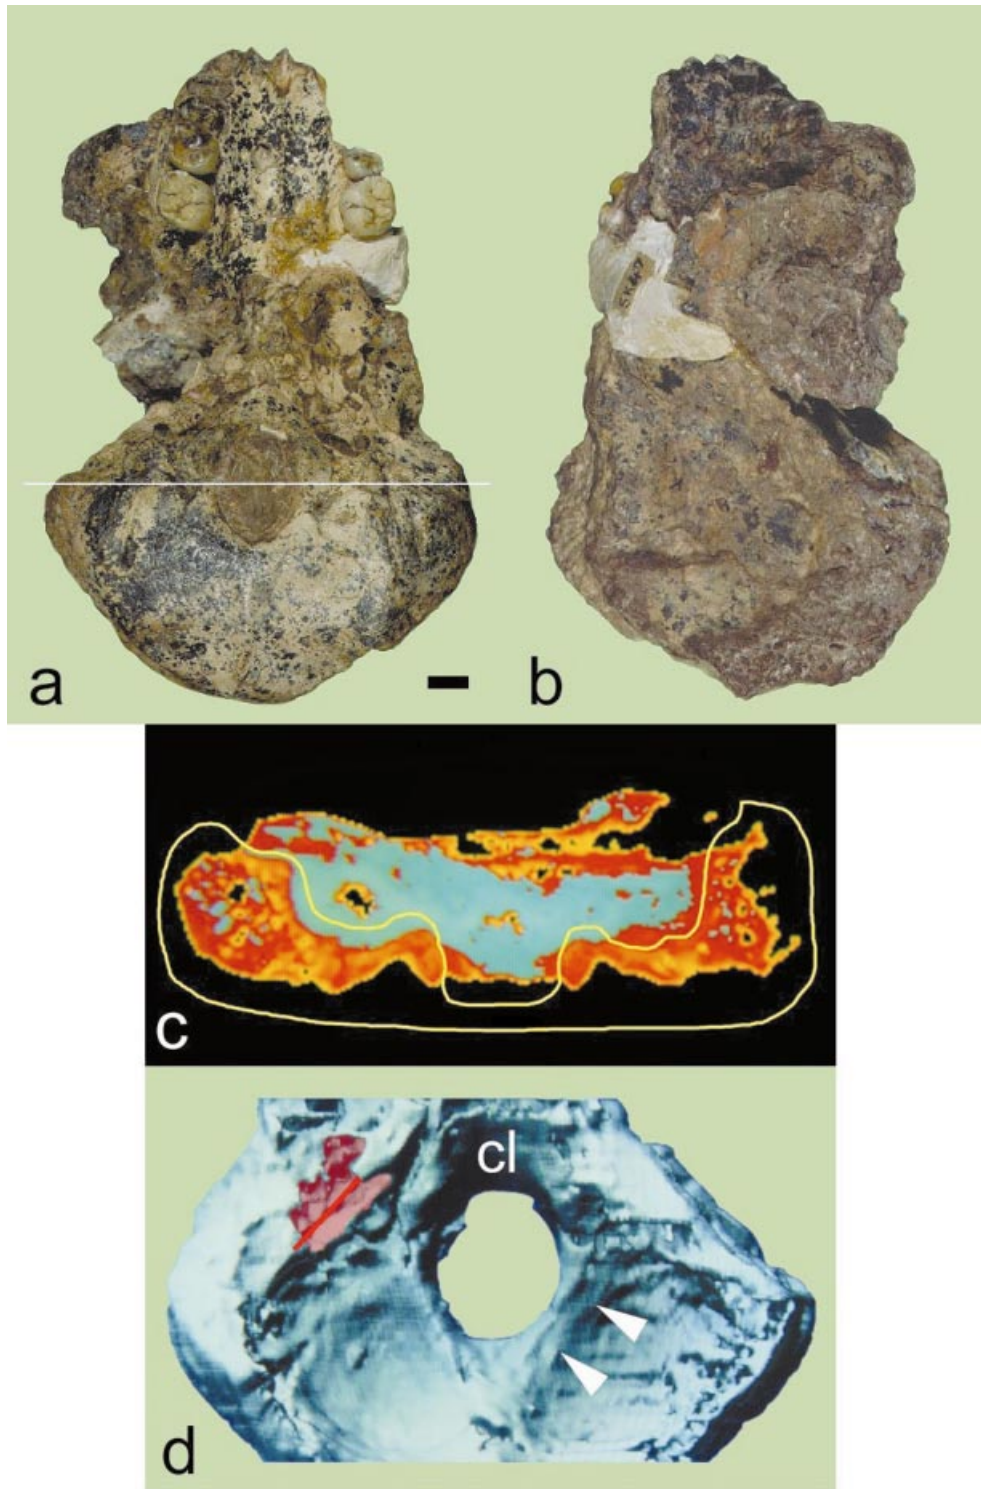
Imaging the *Australopithecus robustus* partial cranium SK 47. (a) Basal view (scale bar is 10 mm). (b) Superior view. (c) Coronal CT scan at the level of the foramen magnum as indicated by the line in a (slice thickness 1.5 mm). Pixels with CT numbers in the range selected for the segmentation of bone are represented in a colour scale, the others in a grey scale. The yellow line is the region of interest (ROI) manually drawn to exclude unwanted areas in the endocranial cavity from the reconstruction. These areas represent bone fragments and matrix with densities in the bone range. (d) Superior view of the surface-rendered 3-D reconstruction of the cranial base with the endocranial matrix and bone fragments removed, showing a groove for the right occipital-marginal sinus (arrowheads). The clivus is indicated (cl), and the reddish area marks an artificial hole in the left petrous pyramid (see text). The red line over this area represents the missing superior margin of the left petrous temporal bone (after Spoor & Zonneveld, 1999).
